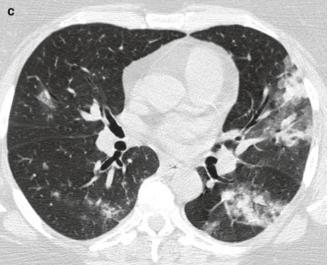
A 54-year-old woman with sinusitis and asthma complicated by Churg-Strauss vasculitis. (a) Frontal chest radiograph shows peripheral opacities in both lungs "photographic negative of pulmonary
